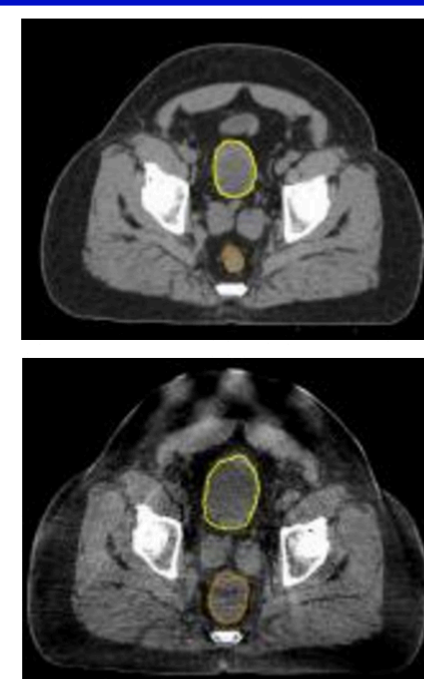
Axial slice of planning CT (top) and daily CBCT (bottom) conveys daily variation of OAR contours bladder (yellow) and rectum (orange).
